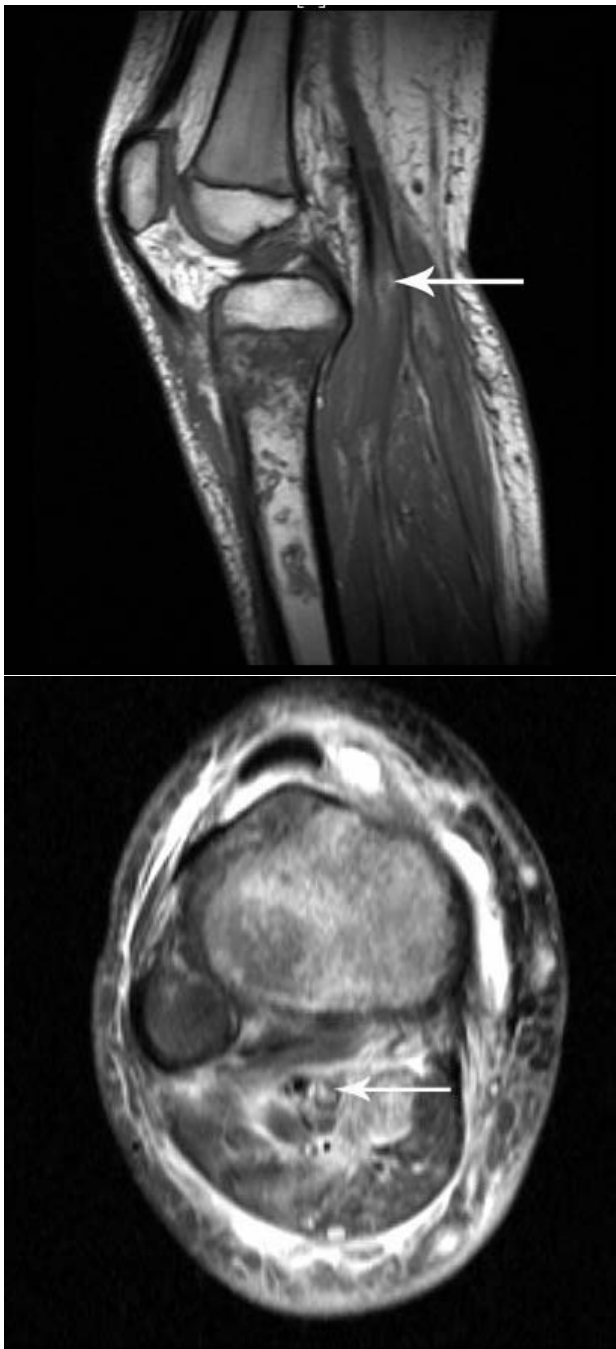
Sagittal and axial MRI images of proximal tibial osteomyelitis with DVT (arrows).
